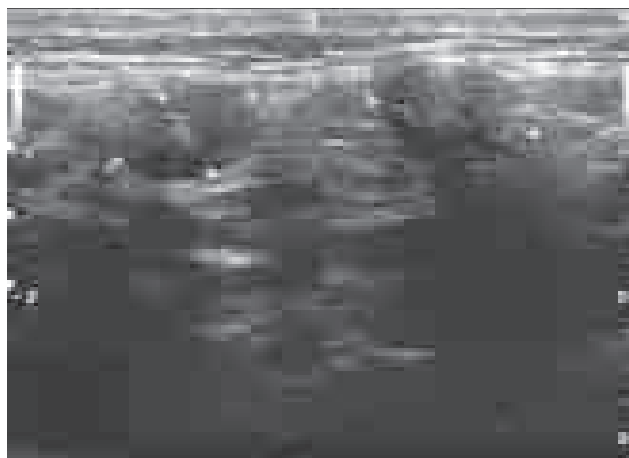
Ultrasonography of the cyst.
